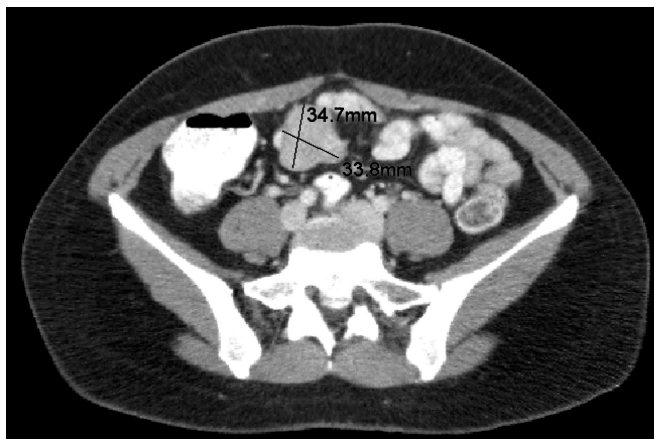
Abdominal CT scan—mass involving small intestine.
